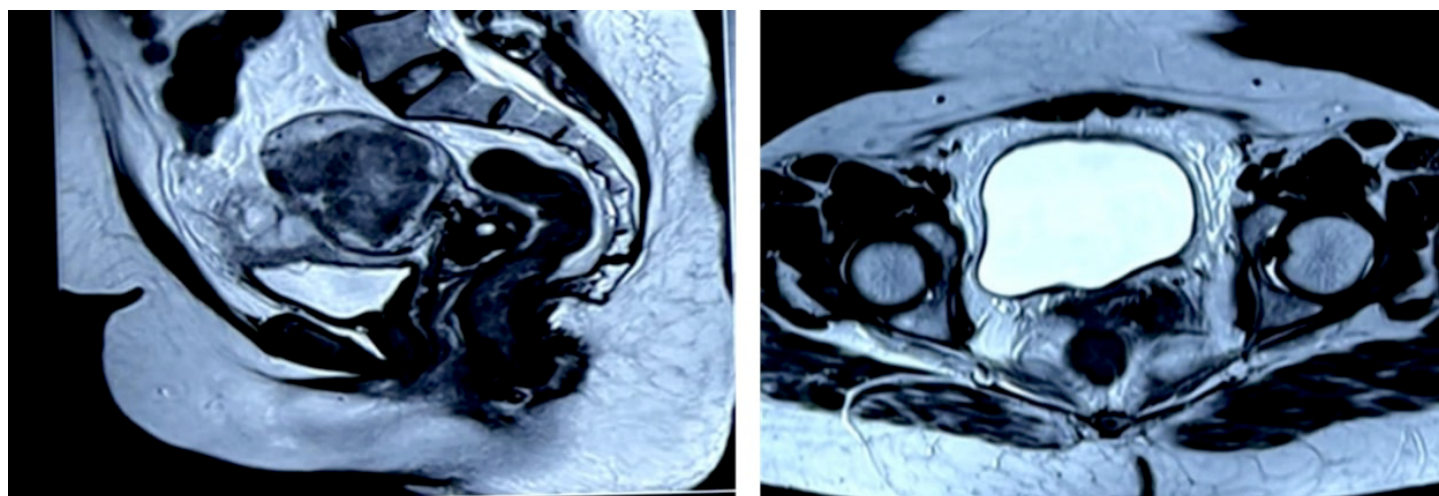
MRI pelvis showing irregular necrotic mass lesion arising from fundus of urinary bladder
